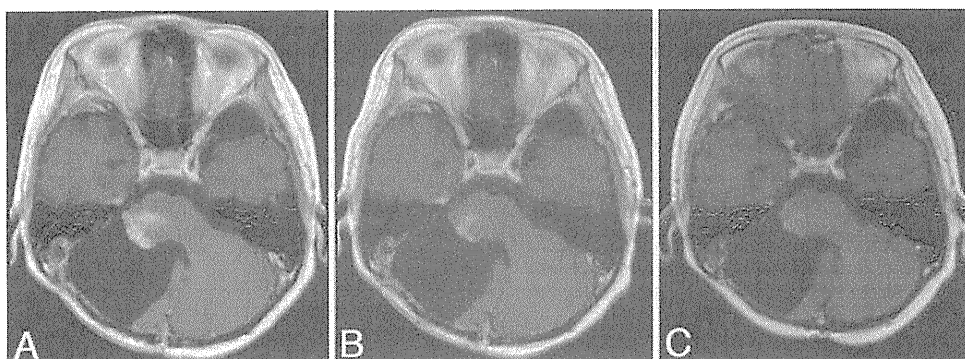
Axial contrast-enhanced T1-weighted MR images obtained 1 week after CED (A), 1 month after CED (B), and 3 months after CED (C).
